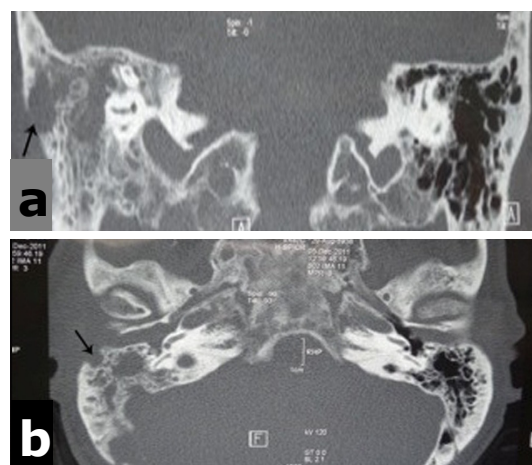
a) CT scans (coronal view), and b) axial view showing loss of normal opacification and diffusely eroded mastoid septation on the right compared to the left side, indicating coalescent disease, with a defect in the external mastoid cortex (arrow).
